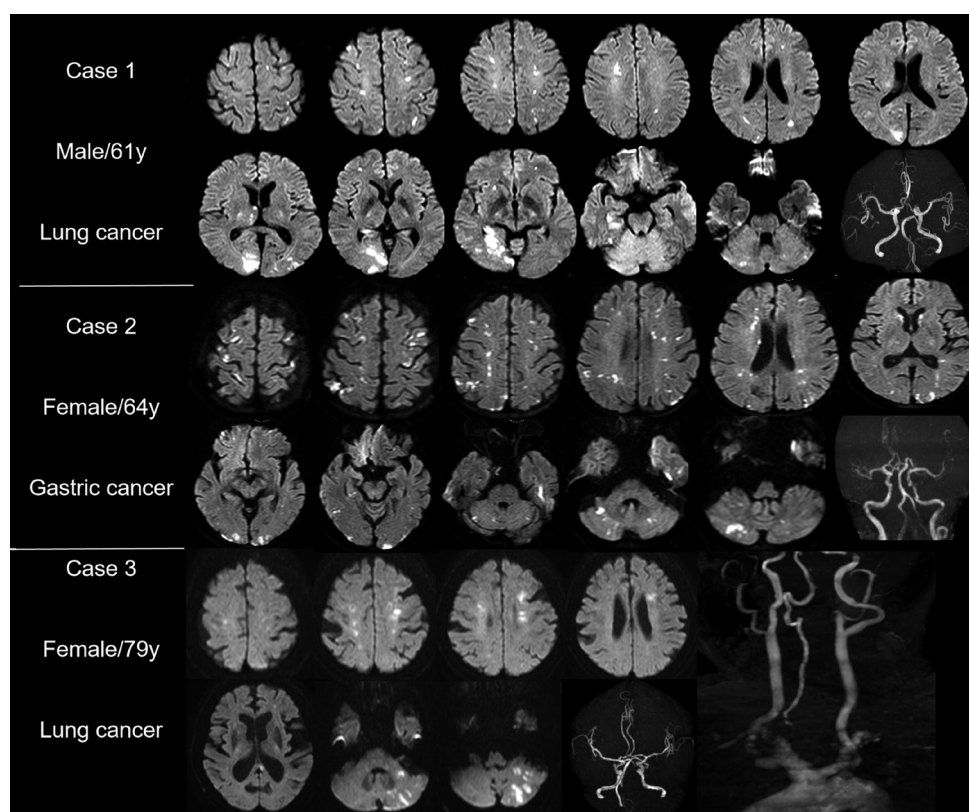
Magnetic resonance imaging pattern of cerebral infarction resulting from Trousseau syndrome. Case 1 was a 61-year-old man diagnosed with lung cancer. Multiple lesions were dispersed in the bilateral frontal lobes, parietal lobes, occipital lobes and cerebellum, as well as the right temporal lobe and right thalamus. Case 2 was a 64-year-old woman diagnosed with gastric cancer. Multiple lesions were dispersed in the bilateral frontal lobes, parietal lobes, occipital lobes and cerebellum, and the bilateral caudate nucleus was even involved. The lesions mostly presented with watershed infarctions. Case 3 was a 79-year-old woman diagnosed with lung cancer. Multiple lesions were dispersed in the bilateral frontal lobes, parietal lobes and the left cerebellum, and the corpus callosum was also involved.
